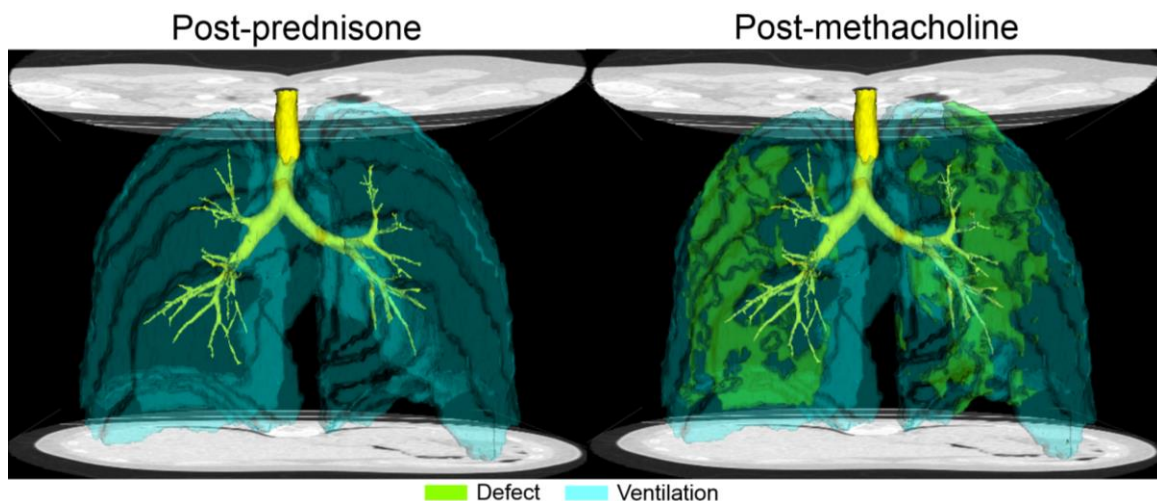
Spatial relationship between ^3He MRI ventilation (blue), ventilation defects (green) and airways (yellow) for a representative subject with severe asthma three days prior to BT while on 50 mg of prednisone.
